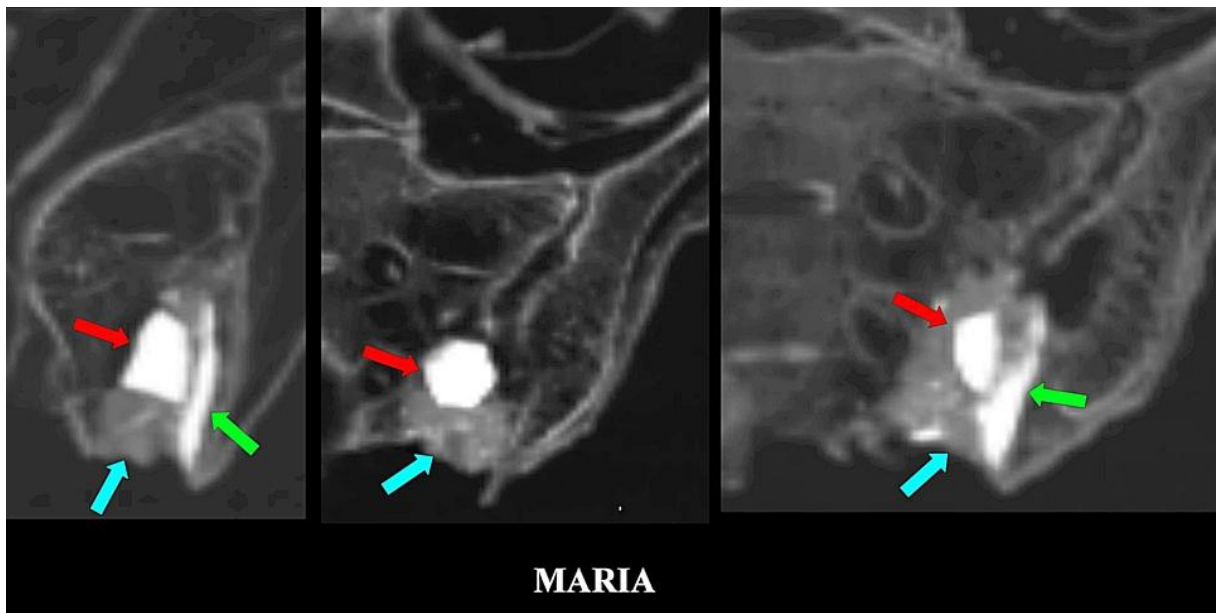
2D sagittal (*left*) and coronal (*middle, right*) CT scans showing the entrance to the bony cavity (*blue arrows*) at truncated edge of the sacrum on the left side extending upwards toward left sacro-iliac joint. The cavity was filled with grit. A hexagonal shaped metallic foreign body (*red arrows*) with an attached plate-like metallic foreign body with rough anterior surface and smooth posterior surface (*green arrow*) was found inside the cavity. Smaller metallic fragment were also noted.
